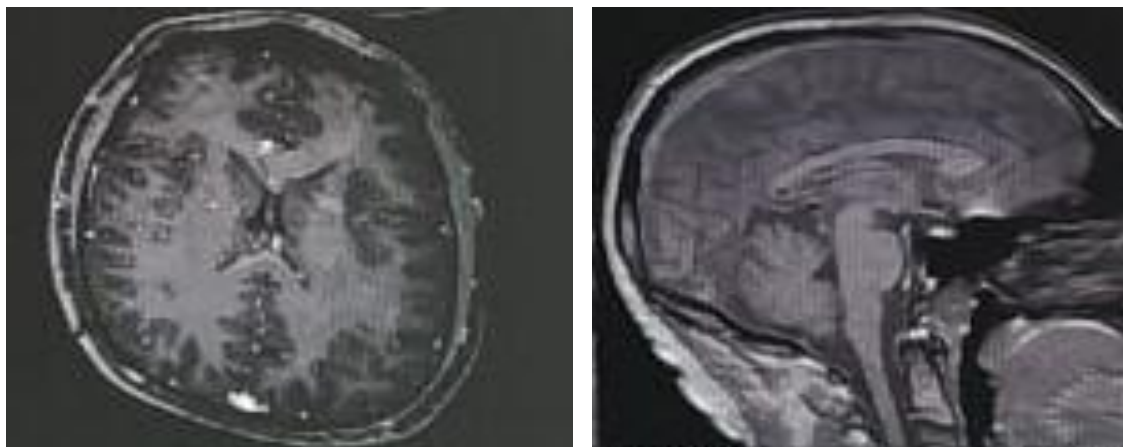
Post-radiotherapy control MRI (Sagittal and Axial section) at 5 years still showing a stable aspect of the pineal region without visible tumor localization.
